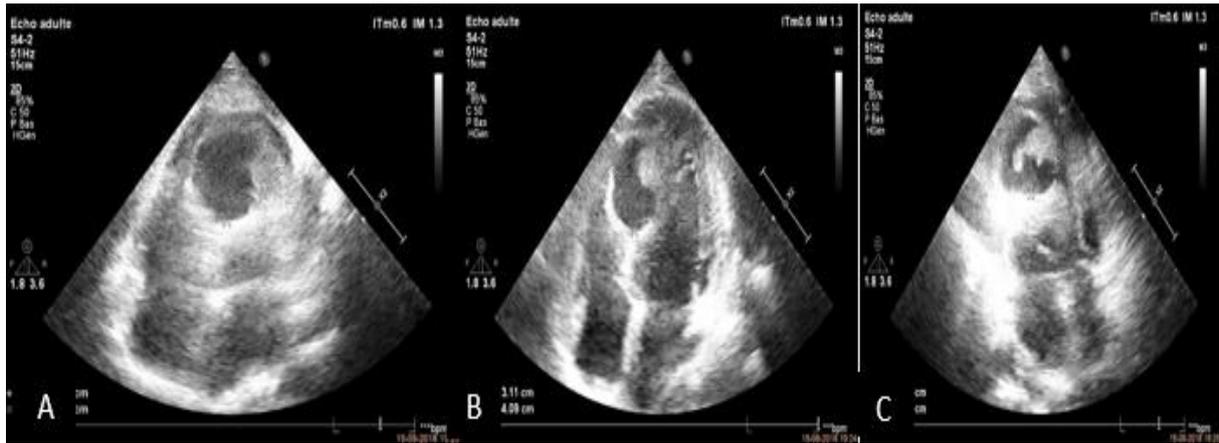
(A)(B)(C): Echocardiographic views showing a cystic image with thickened wall, in the inferolateral and inferior wall of the left ventricle.
